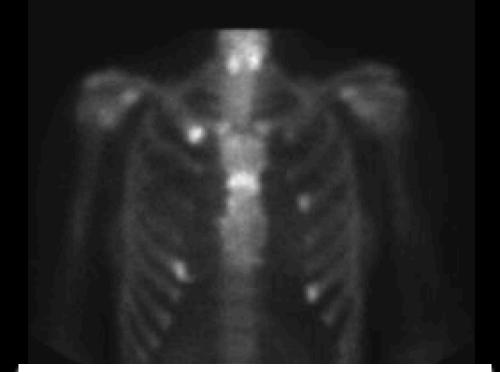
Bone scintigraphy: multiple signs of costochondritis (2013)
